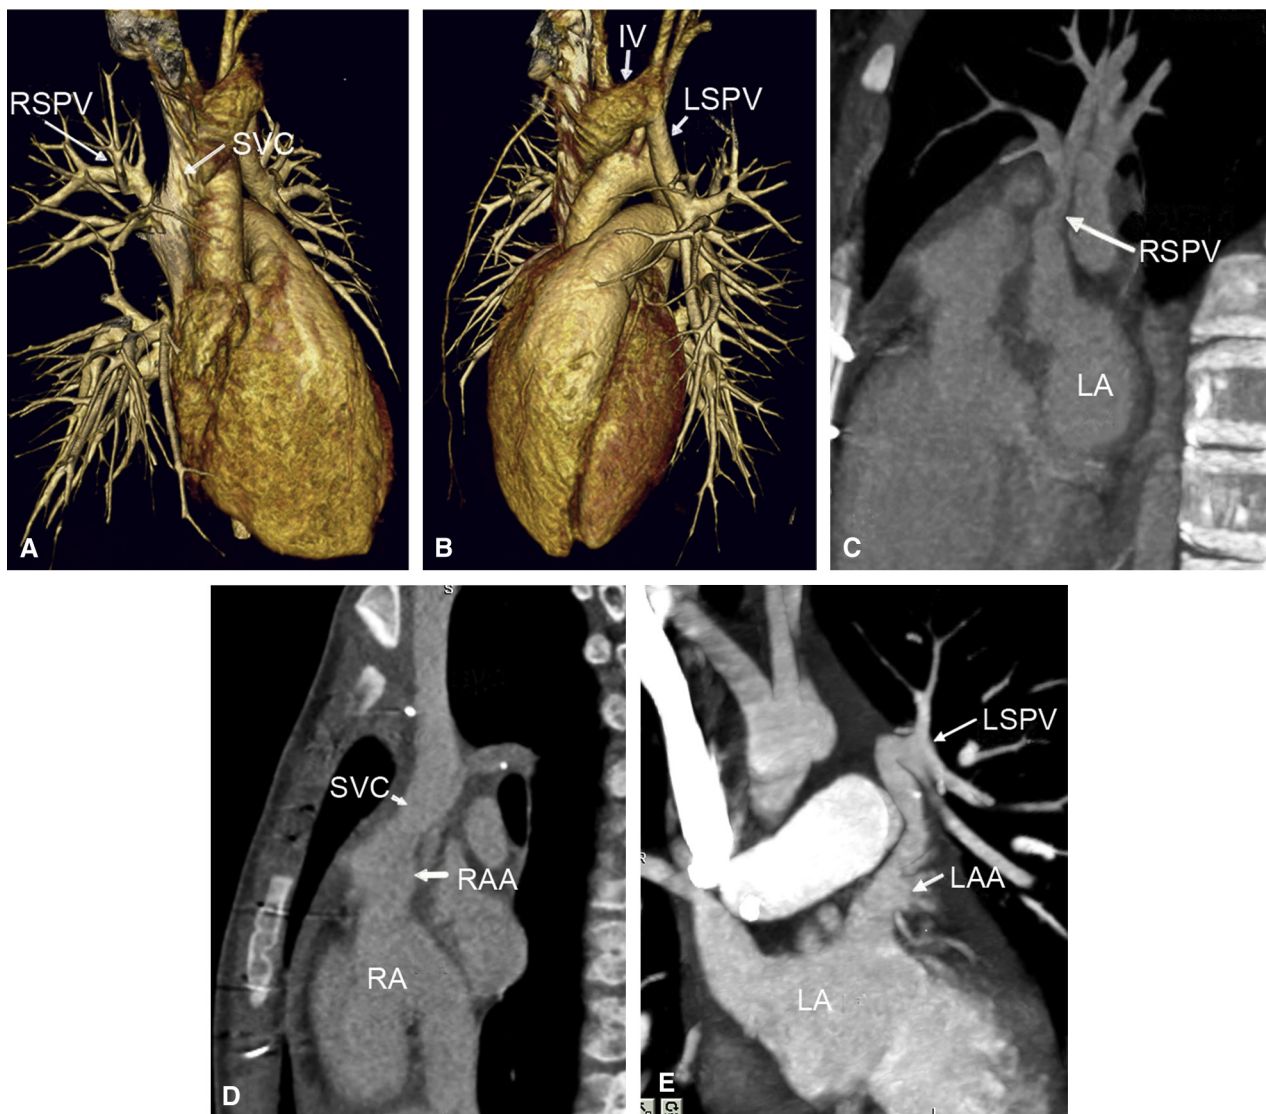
Angiographic computed tomography results. Preoperative angiographic view of (A), the right superior pulmonary vein (RSPV) connected very high to the superior vena cava (SVC) and (B), the left superior pulmonary vein (LSPV) connected to the innominate vein (IV). Postoperative angiogram of (C), the new connection between the RSPV and the left atrium (LA), (D), the SVC connection to the right atrial appendage (RAA), and (E), the connection of the left superior pulmonary vein to the left atrial appendage (LAA). RA, Right atrium.
